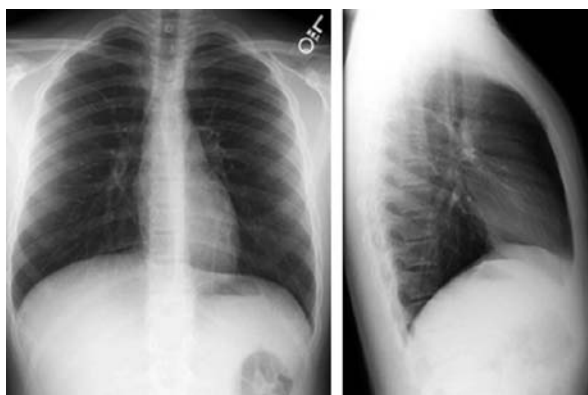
Chest X-ray (CXR) of a 63-year-old male patient
